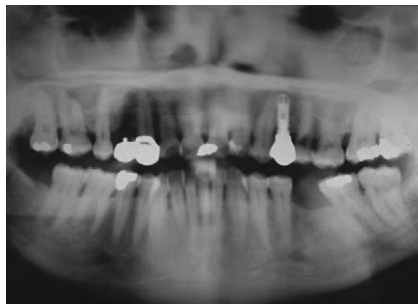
Follow-up radiograph 1 year in function.
